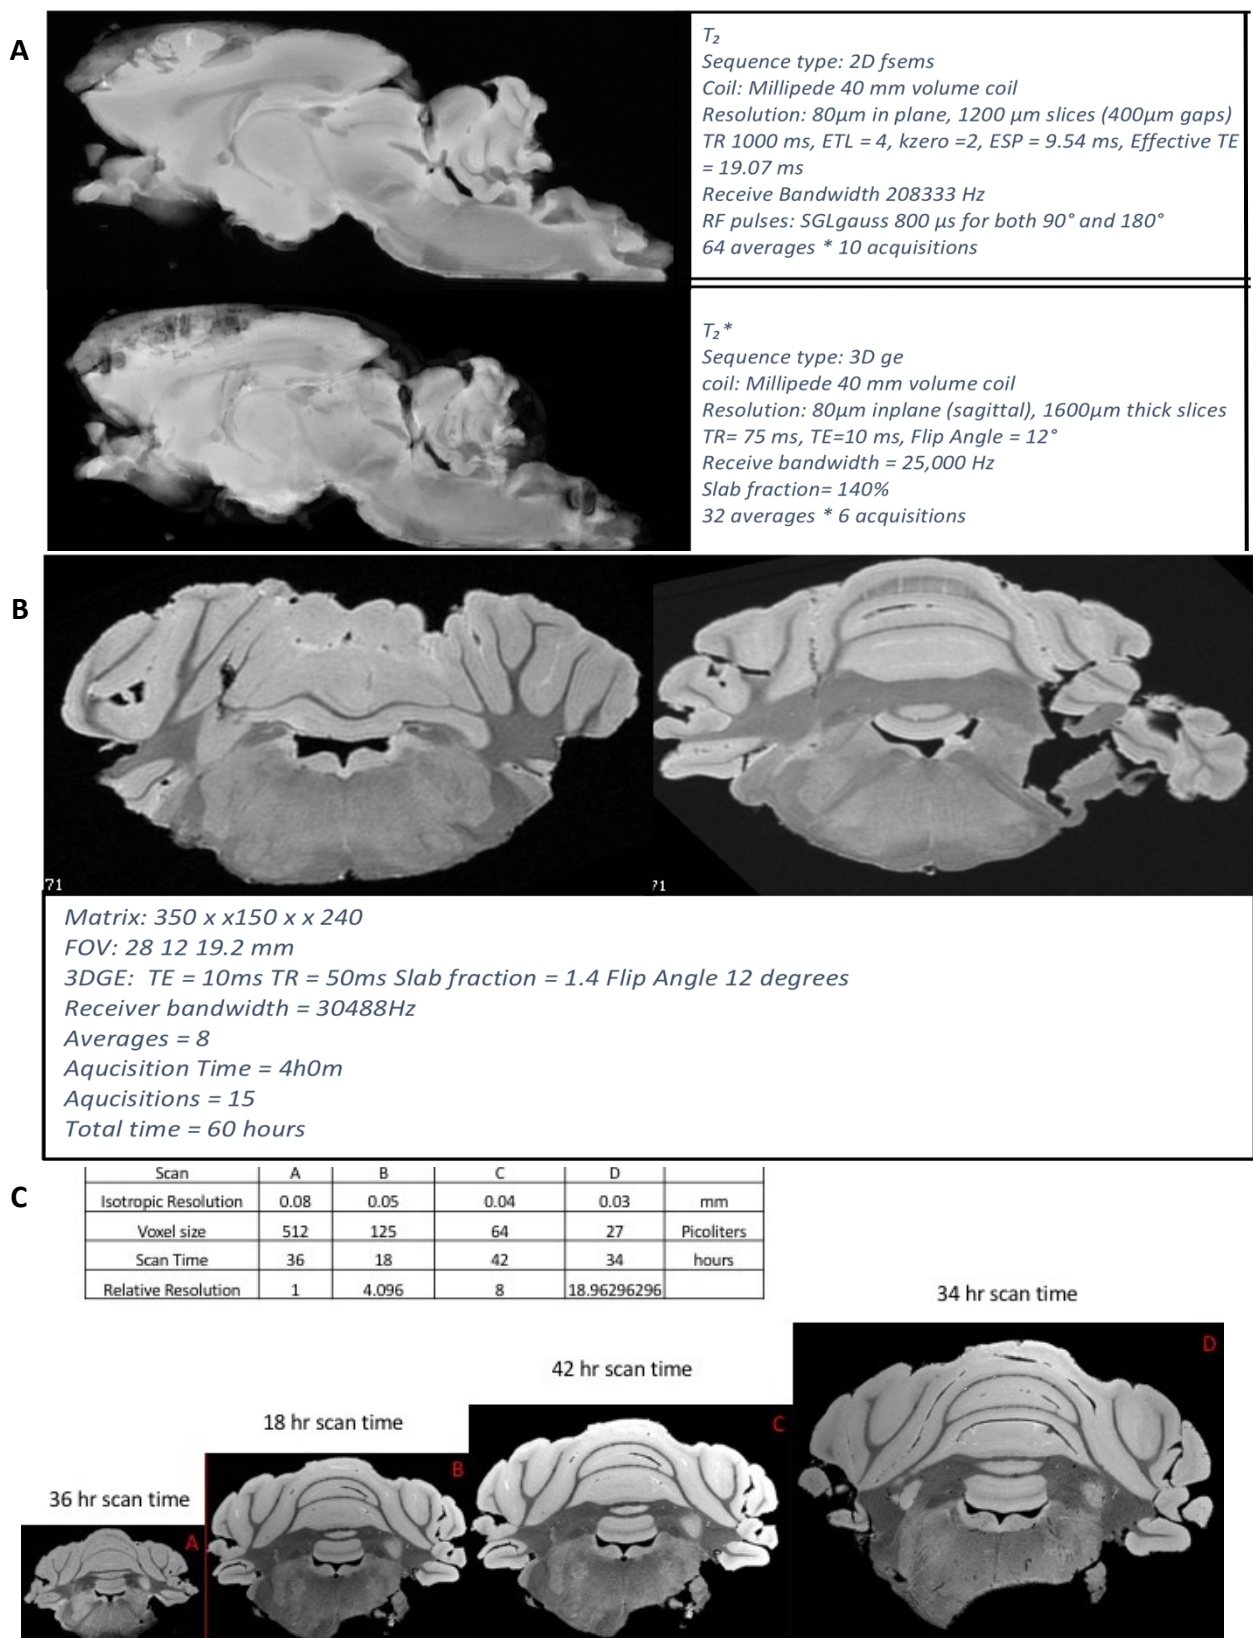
Example images of ex vivo MRI of cerebellae used in the development of the ex vivo imaging methodology. A shows early attempts using both T2 and T2* sequences, with B showing the more refined sequences and improved image quality. C shows the sequence development and the improvement in resolution. Imaging was performed in the 9.4T horizontal magnet. Studies performed with J.Guy.
